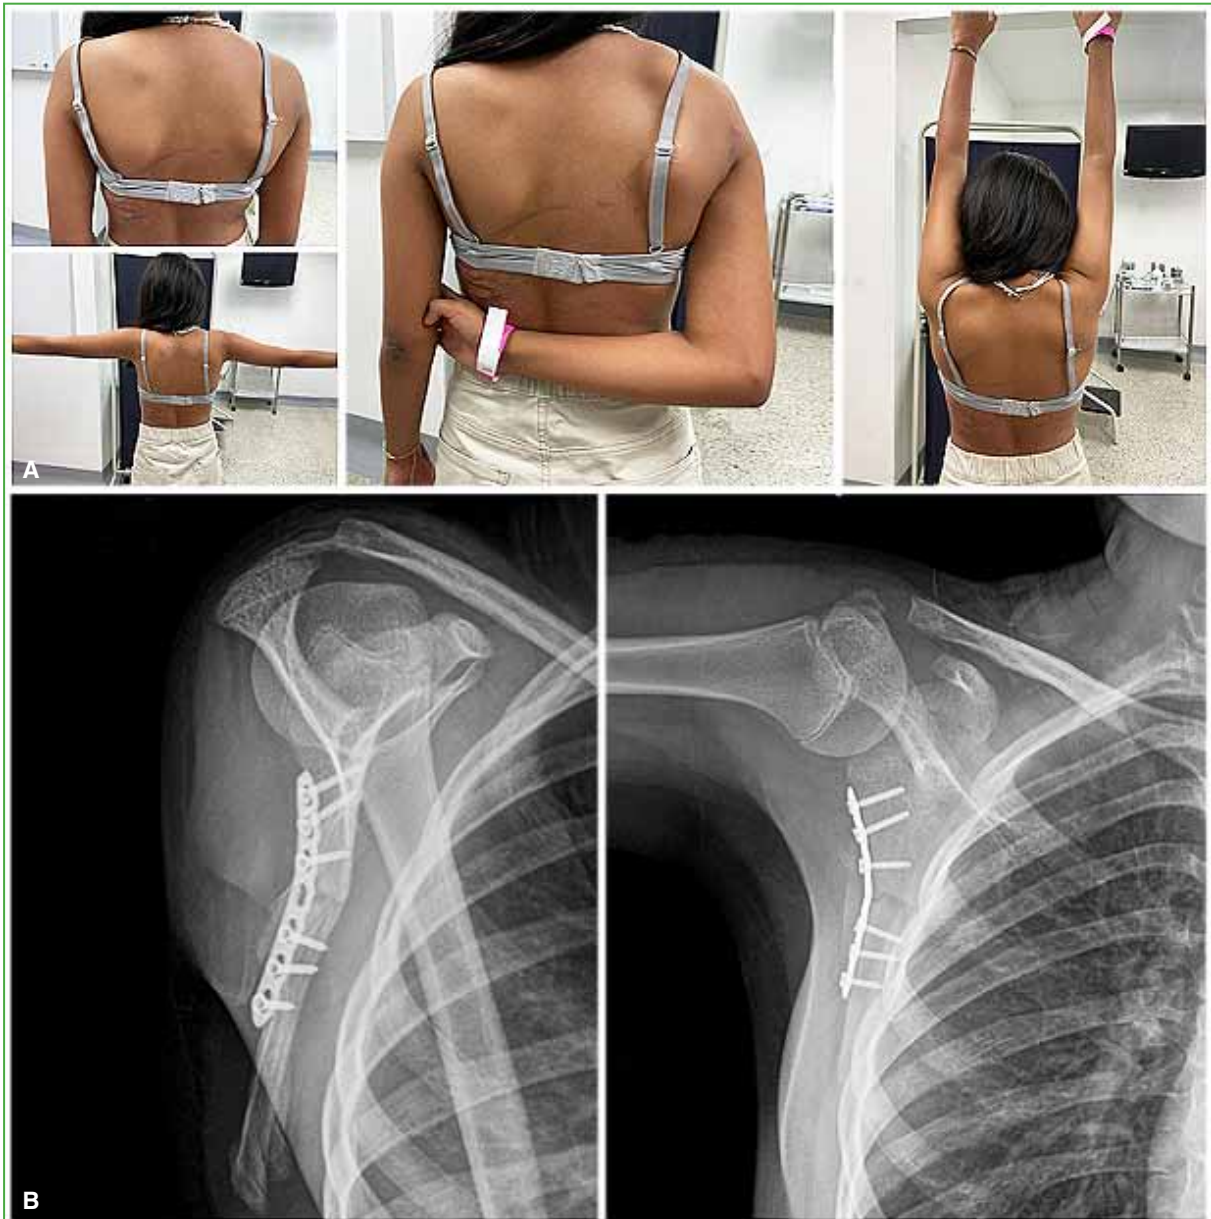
A. Clinical postoperative images. Symmetrical right shoulder with acceptable scarring and full functional capacity, without limitation in abduction, adduction, elevation, external rotation, or internal rotation, with ranges of motion comparable to the contralateral side. B. Anteroposterior and lateral scapular radiographs. Adequate positioning of the hardware, with no signs of loosening or instability; fracture site aligned and progressing toward consolidation.
